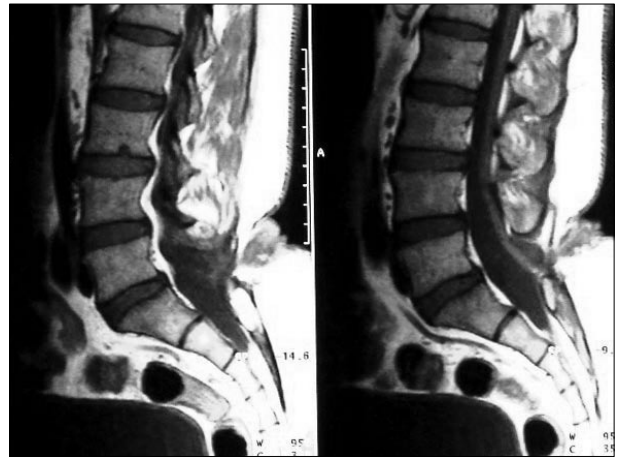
Sagittal T1-weighted MR images demonstrated myelocoele sac originated from L5 spina bifida. Notice that conus medullaris reached L5 level and extension of the filum terminale terminated within the meningocele.
